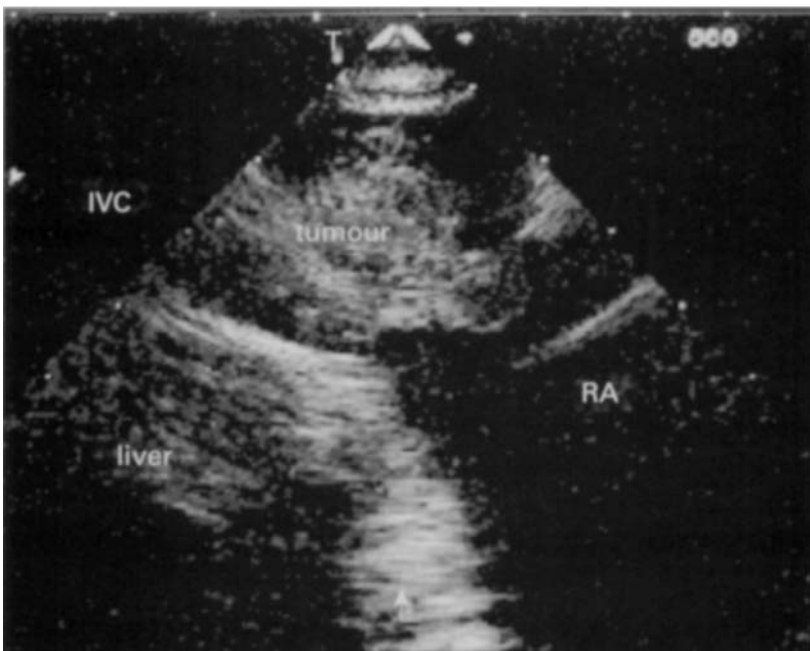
Transoesophageal echocardiogram showing renal cell carcinoma extending into the inferior vena cava (IVC) up to the right atrium (RA).
